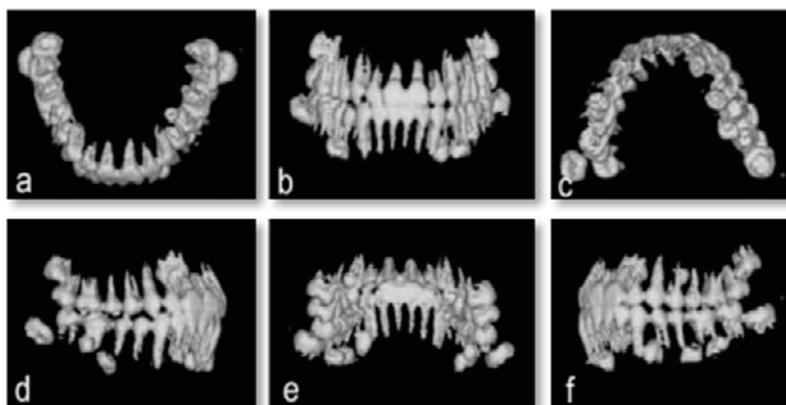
3D CT images of the both dentitions show the exact location and potential eruption orientation of the supernumerary teeth.
